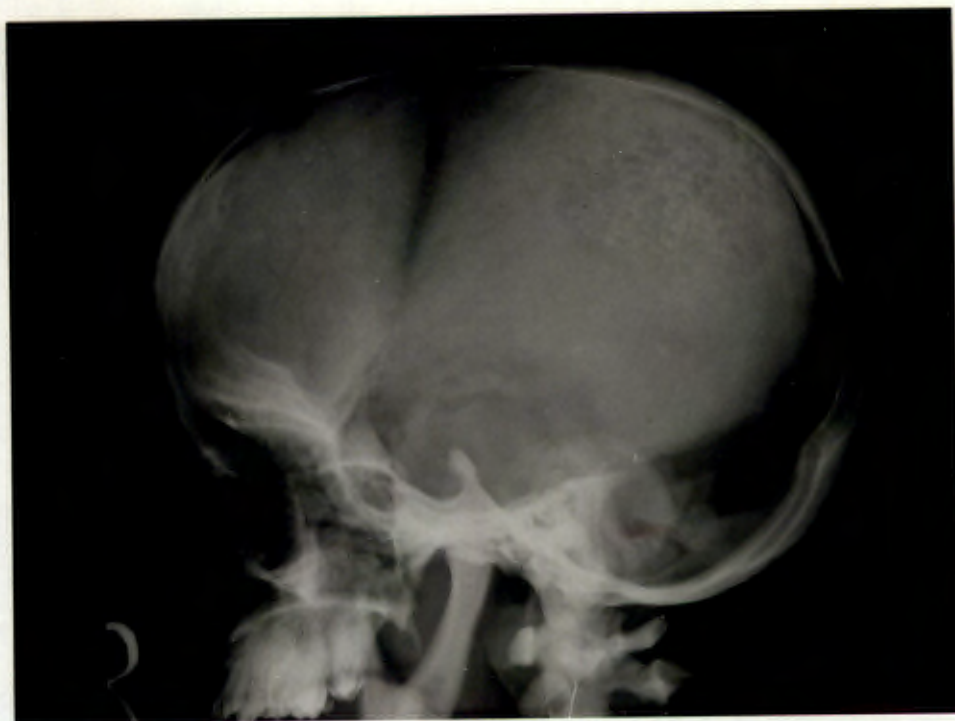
Lateral radiograph of the skull in pyknodysostosis: The osteosclerosis, open sutures, small mandibular angle and prominence of the occipital and frontal bones is evident.
